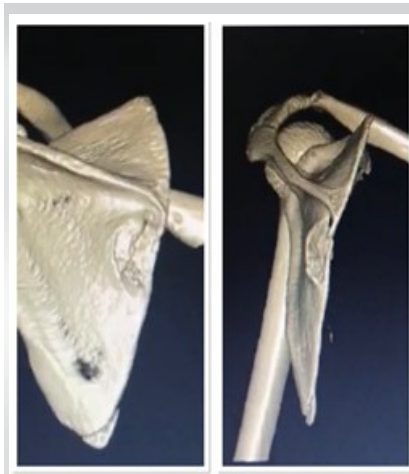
Post-operative computed tomography images showing complete excision of osseous mass.
